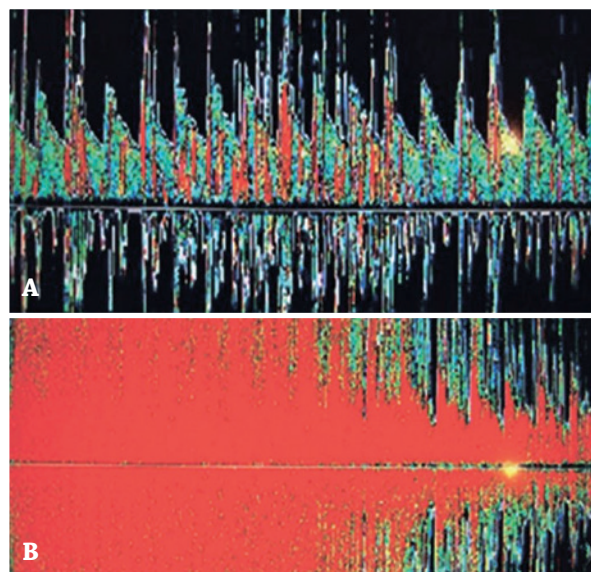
Transcranial Doppler. Shower pattern (A). Curtain pattern (B).
